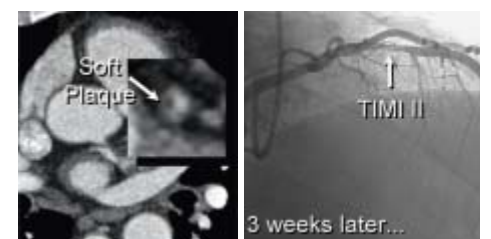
Lipidrich (vulnerable) plaque in the left anterior descending coronary artery as detected by coronary computed tomography (arrow left). Three weeks later the patient experienced a myocardial infarction caused by a culprit lesion at the same location (arrow right).
